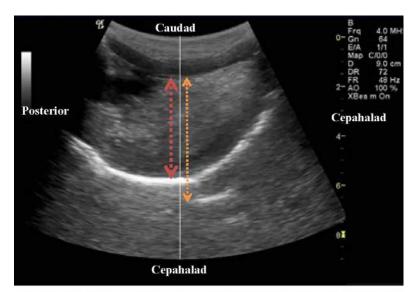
Sagittal ultrasound scan of the oral cavity. Red arrow designates tongue thickness; orange arrow designates oral cavity height.
